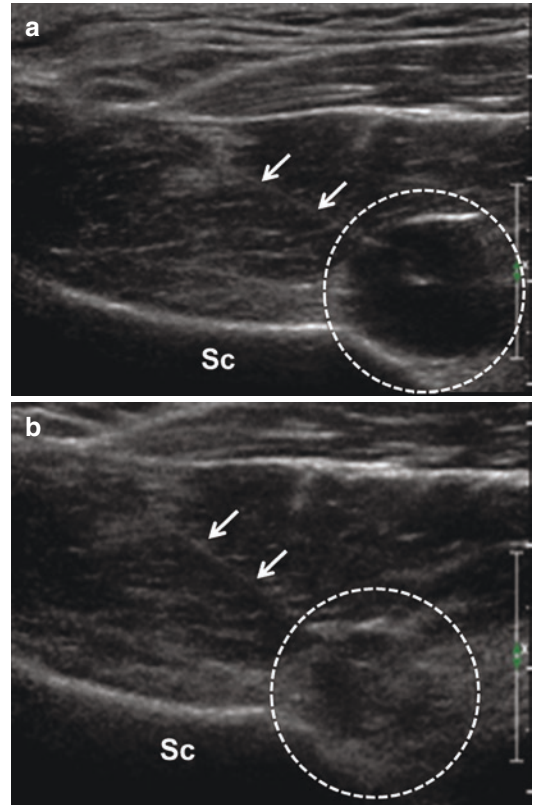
Ultrasound images (a, b) demonstrating a needle (arrows) within the spinoglenoid notch cyst (circles). Post-aspiration (b), there is decompression of the spinoglenoid notch cyst
